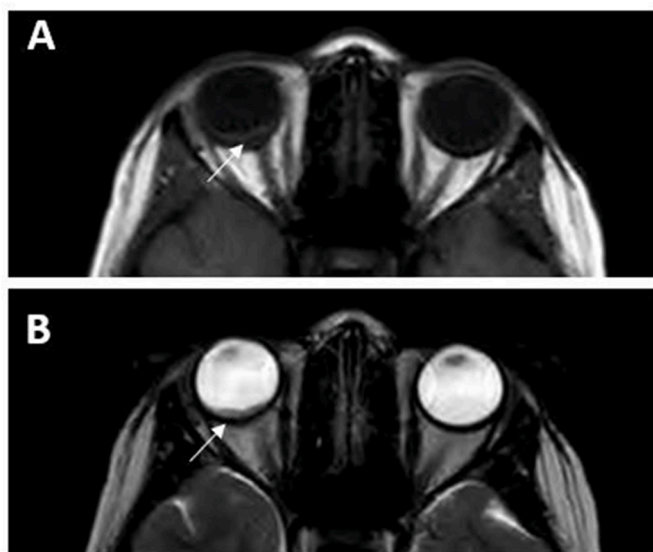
Contrast-enhanced MRI demonstrating a plaque-like lesion lining the posterior pole of the right globe correlating with the exudative retinal detachment, which was hyperintense in T1-weighted image A and hypointense in T2-weighted image B (white arrow).
